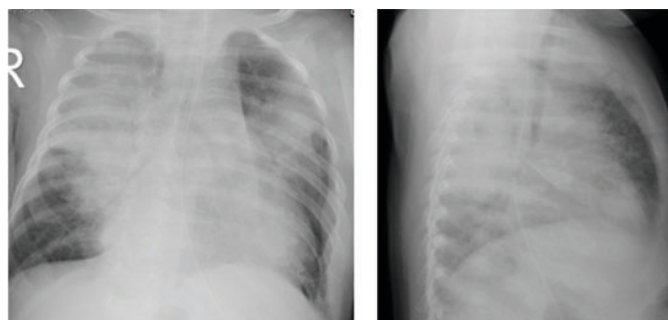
Chest X-rays on the 5th day showed progression of pneumonia with consolidation and concomitant adenopathy.
